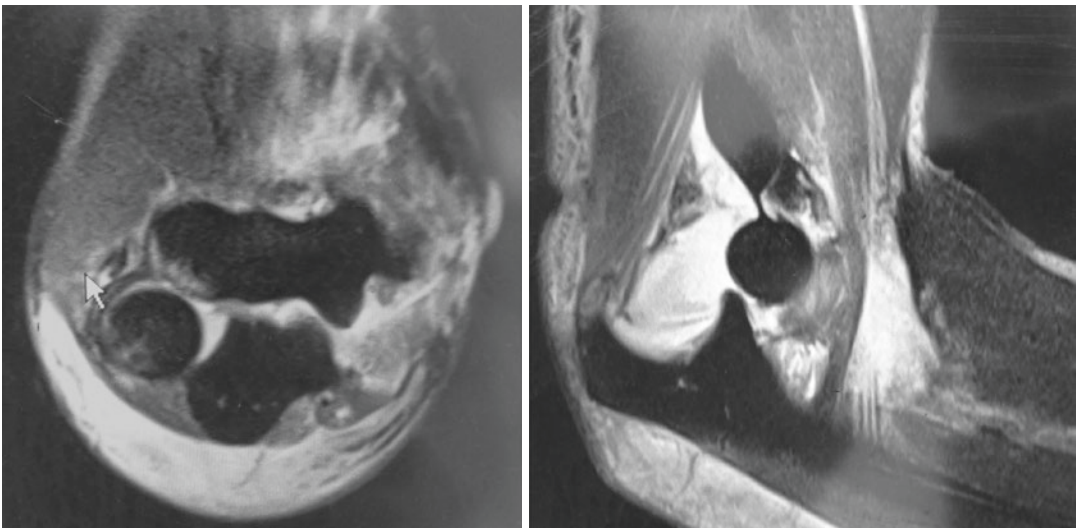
51-year-old male patient after skiing accident: MRI showing re-dislocation of the elbow joint within the applied plaster cast. The brachialis muscle and the flexor-pronator-mass are totally ruptured
